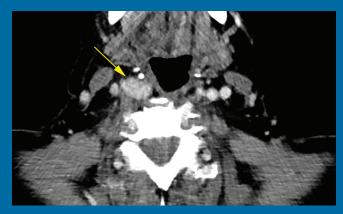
CT image demonstrating the possible presence of carotid body tumor (yellow arrow).
